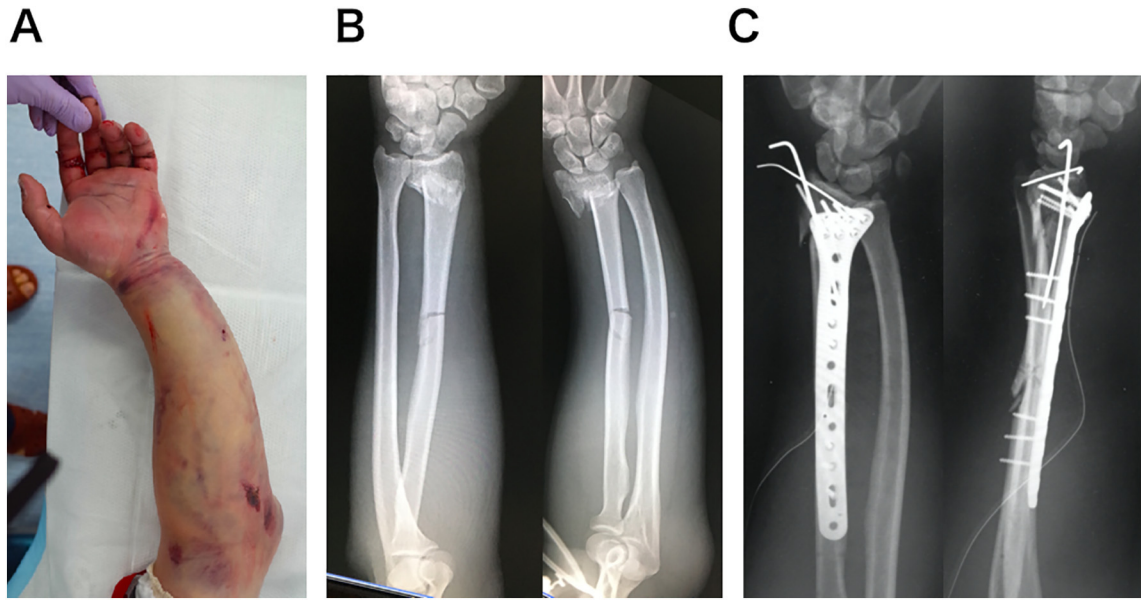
A) The left forearm of the patient is clearly deformed. B) Radiography shows fractures at the distal and middle radius, and plastic bowing of the ulna. C) Osteosynthesis for the radial fracture was performed 3 weeks after the injury. The radial fractures are fixed with a locking plate and wires. The ulna shows remnant plastic bowing deformity.
